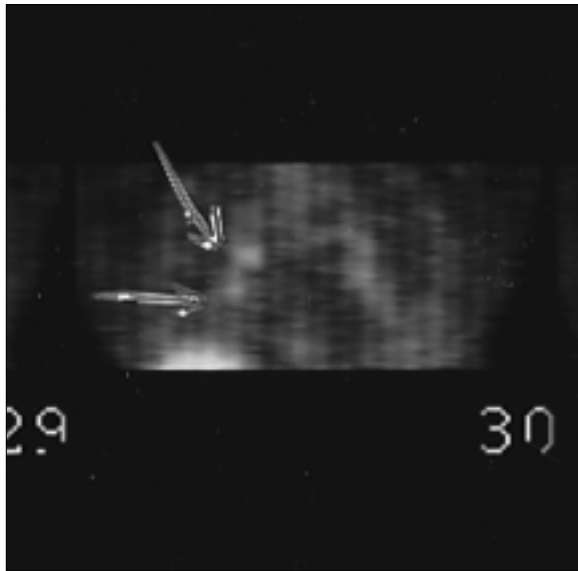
A. Seventy-one-year old female with history of chest pain and shortness of breath for 3 weeks. CT shows a 2-cm nodule of the left lung base and two small 5-10 mm nodules, one at the upper lobe and one in the right lower lobe. There is some mild right hilar adenopathy and a small enlarged lymph node. All are of indeterminant etiology.
